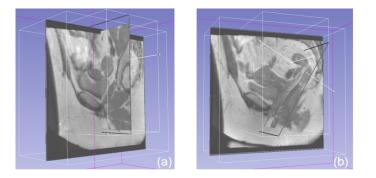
3D view of MRI stack using 3D Slicer. (a) Sagittal and Coronal plane make a normal angle. (b) Coronal plane has been rotated to a normal angle to PVM's fiber direction
